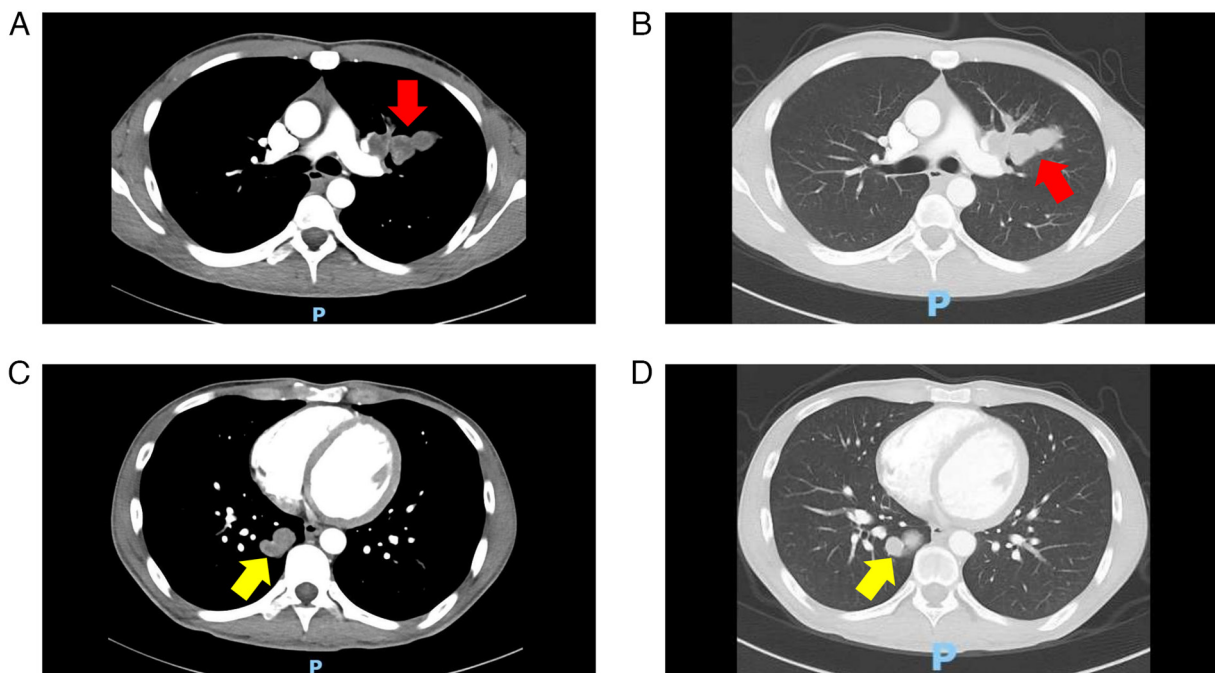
Chest CT scan (November 2024). Multiple metastatic nodules are visible in both lungs, with larger lesions located in (A and B, red arrows) the left upper lobe anterior segment and (C and D, yellow arrows) the right lower lobe basal segment. (A) Mediastinal window CT demonstrating a larger metastatic lesion (red arrow) in the left upper lobe anterior segment. (B) Lung window CT showing the same metastatic nodule (red arrow) with clear visualization of its relationship to the surrounding pulmonary parenchyma. (C) Mediastinal window CT revealing a larger metastatic lesion (yellow arrow) in the right lower lobe basal segment. (D) Lung window CT displaying the same metastatic nodule (yellow arrow) with optimal demonstration of its pulmonary context. P, posterior.
